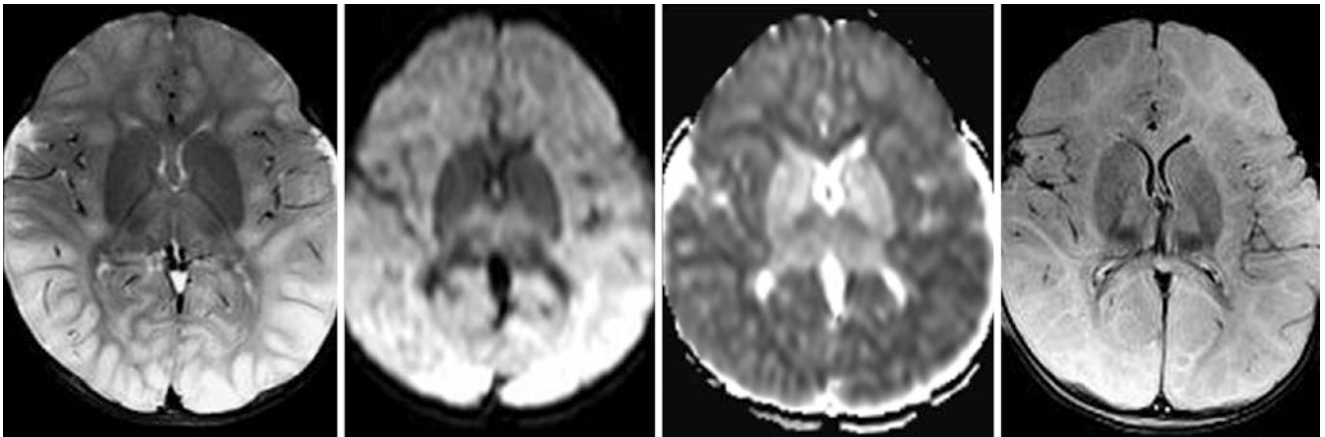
Comparison case of urea cycle disorder (UCD, ornithine transcarbamylase deficiency). An 11-month-old with acute encephalopathic symptoms had diffuse cerebral edema on a 3T MRI with SE T2WI (*left*). On DWI (*left middle*) and the corresponding ADC map (*right middle*), the edema was confirmed to be cytotoxic in nature. On a follow-up MRI 6 days later, FLAIR (*right*) showed persistent diffuse
